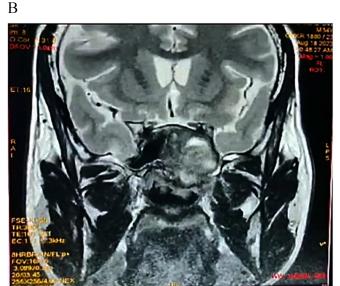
Magnetic resonance imaging in the multiple sagittal section (A) and coronal section (B) reveal a hyperintense lesion occupying the left clivus and is seen extending into the pituitary fossa.
